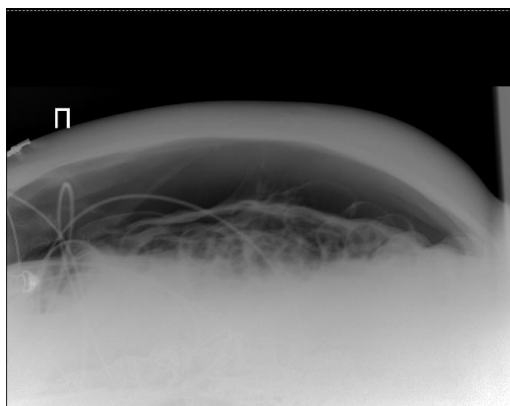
Horizontal abdominal X-ray showing free intraperitoneal air, characteristic of pneumoperitoneum
